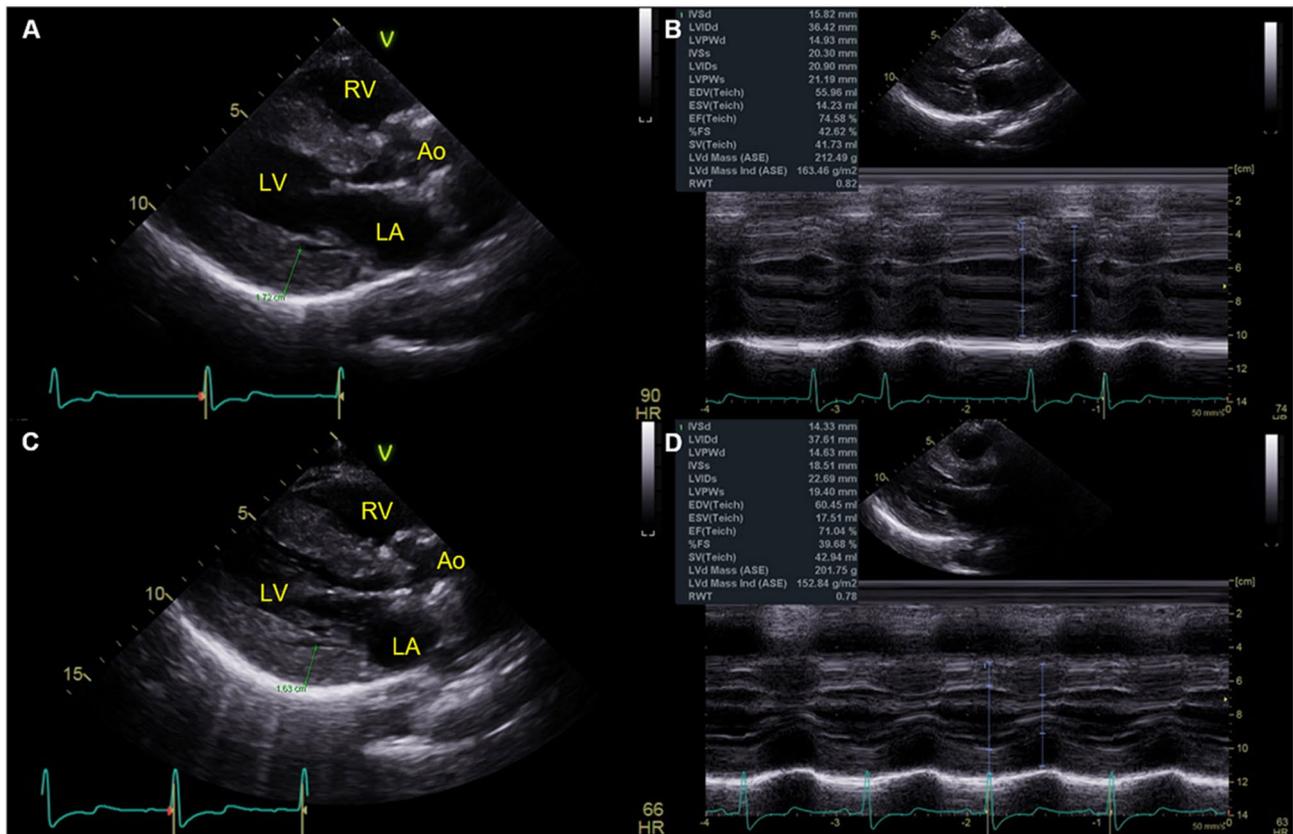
Echocardiography before enzyme replacement therapy showed left ventricular hypertrophy with a posterior wall thickness of 17.2 mm in parasternal long axis view (A) and left ventricular mass index of 163.5 g/m² on M-mode echocardiography (B). Follow-up echocardiography after enzyme replacement therapy showed a mild regression of left ventricular hypertrophy with a posterior wall thickness of 16.3 mm (C) and left ventricular mass index of 152.8 g/m² (D). LV, left ventricle; RV, right ventricle; LA, left atrium; Ao, aorta
